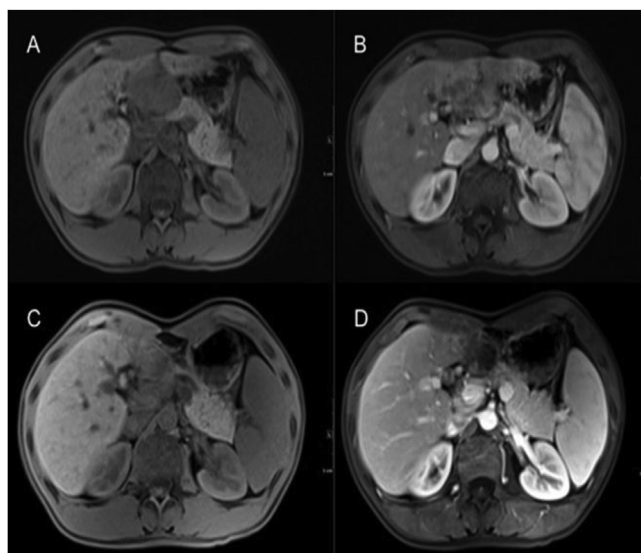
Hepatocellular carcinoma in the left hepatic lobe with thoracic spine metastasis in a 28-year-old man. A and B: Preoperative enhanced magnetic resonance images showing large left-lobe lesions. C and D: Enhanced magnetic resonance images showing tumor necrosis at 1 month after surgery.
